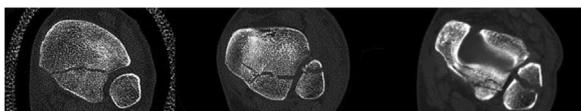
Axial computed tomography (CT) images of the three different posterior malleolar ankle fractures according to the fracture classification system of Haraguchi et al. On the left a Haraguchi Type I fracture with a triangular fragment involving the posterolateral corner of the tibial plafond. In the middle a Haraguchi Type II fracture with extension of the fracture line into the anterior part of the medial malleolus, which results in a posterolateral and a posteromedial fragment. On the right a Haraguchi Type III fracture with a small shell-shaped fragment at the posterior lip of the tibial plafond.
